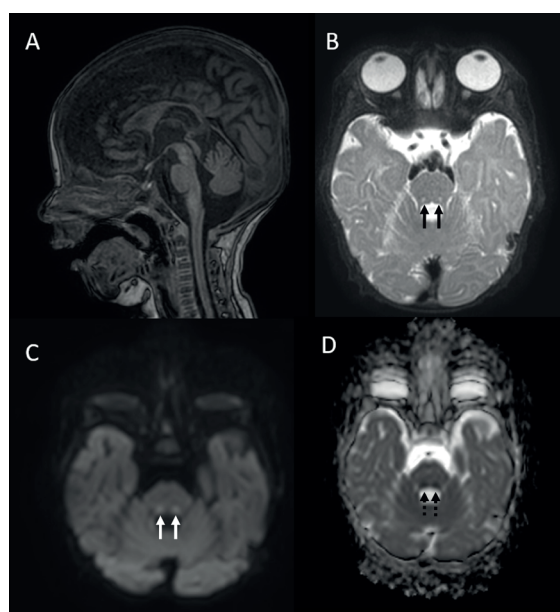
Brain MRI of the patient at 4 months-old. Sagittal T1-weighted (W) image (A) shows mild inferior vermian hypoplasia, elongated midbrain and thin corpus callosum. Axial T2-W image (B) shows bilateral T2 hyperintensity of central tegmental tracts in the pons (arrows) and diffusion restriction as demonstrated by hyperintensity on trace diffusion (C) and low ADC values on ADC map (D).
